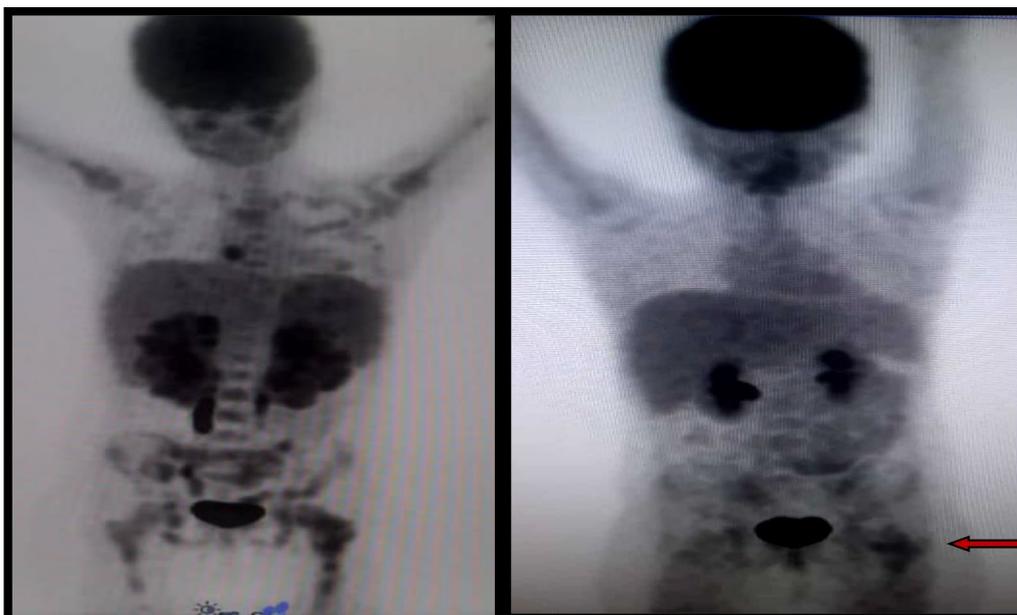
PET-CT study for an 8-year-old female child presented with fever and abdominal pain. Abdominal US revealed bilateral kidney masses that were pathologically proved to be non-Hodgkin's lymphoblastic lymphoma. To the left: Initial study shows metabolically active FDG-avid infiltrates involving both kidneys, bone marrow, and bone. To the right: Interim PET-CT study shows complete disappearance of all lesions except a residual bone marrow lesion at left femur with SUVmax ~ 2.63. The visual interpretation of this study using 5P-DS was positive (score 4) as left femoral activity was higher than that of liver, while it was negative using rDS (rDS = 1.05) which is less than the cutoff point (liver max ~ 2.5). The follow-up showed complete cure of the patient (35 months)
